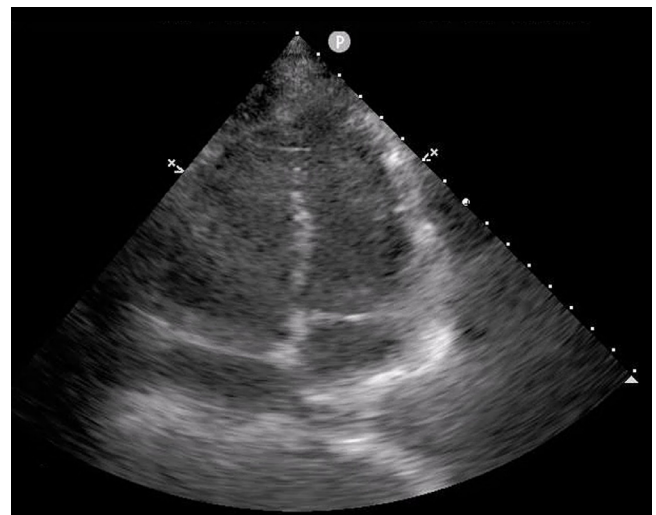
Apical 4-chamber view demonstrating an enlarged right ventricle consistent with elevated intravascular volume.
